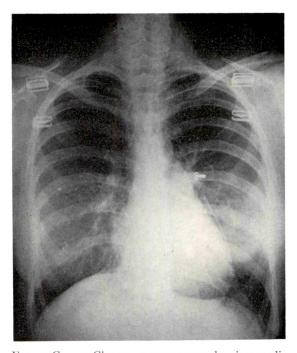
Case 1. Chest roentgenogram showing mediastinal emphysema and cervical subcutaneous emphysema.
